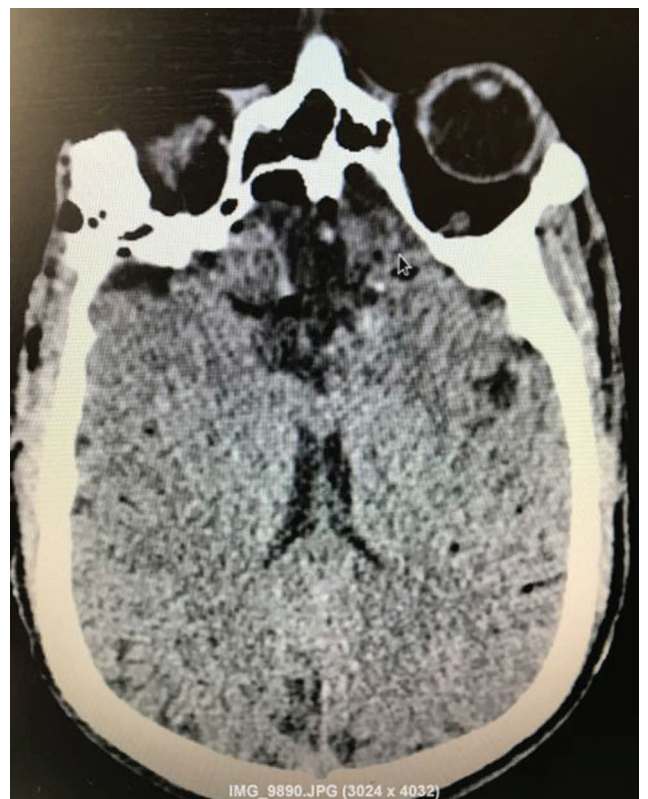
Postoperative CT scan after resection of the lesion.
